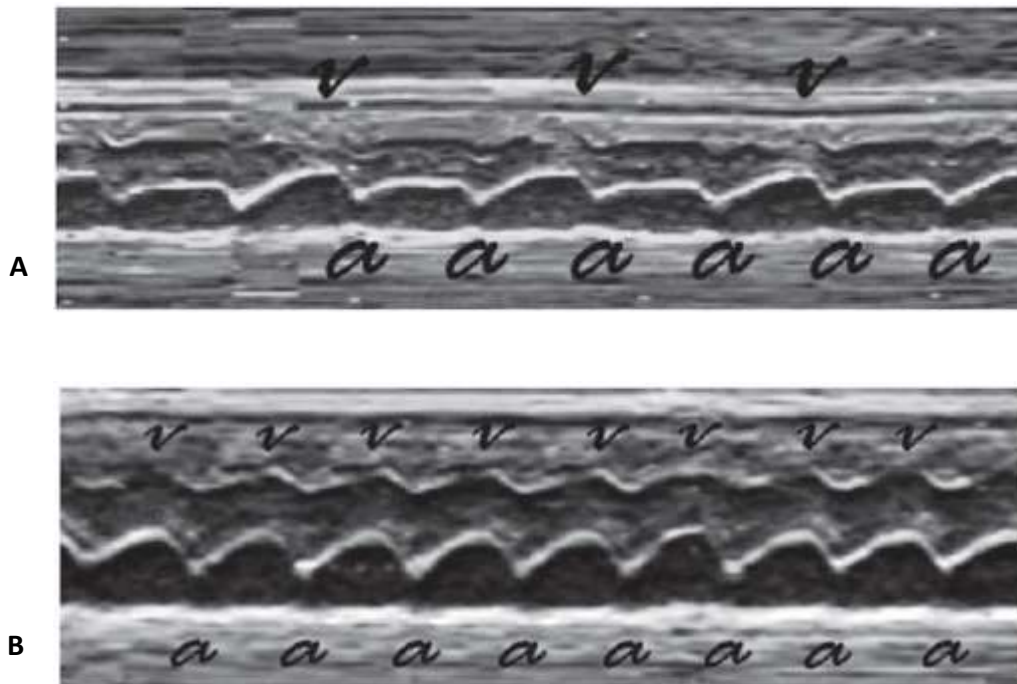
M-mode fetal echocardiography recordings. A) At the 20th week, the finding of an second-degree atrioventricular (AV) block. B) At the 26th week there was a normal sinus rhythm after five weeks of betamethasone, five plasmaphereses, and one intravenous immunoglobulin (IVIG) infusion. a: atrial contraction, v: ventricular contraction.
